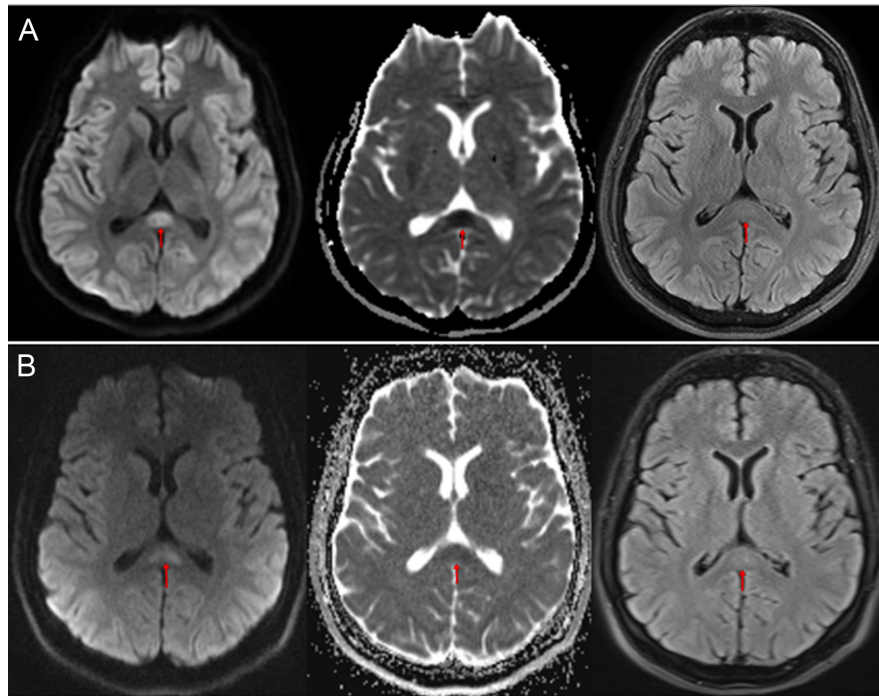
(A) Diffusion-weighted image hyperintense, apparent diffusion coefficient hypointense, and FLAIR mild hyperintense area in the splenium of the corpus callosum. (B) Decrease in findings in the same localization after 4 days.
